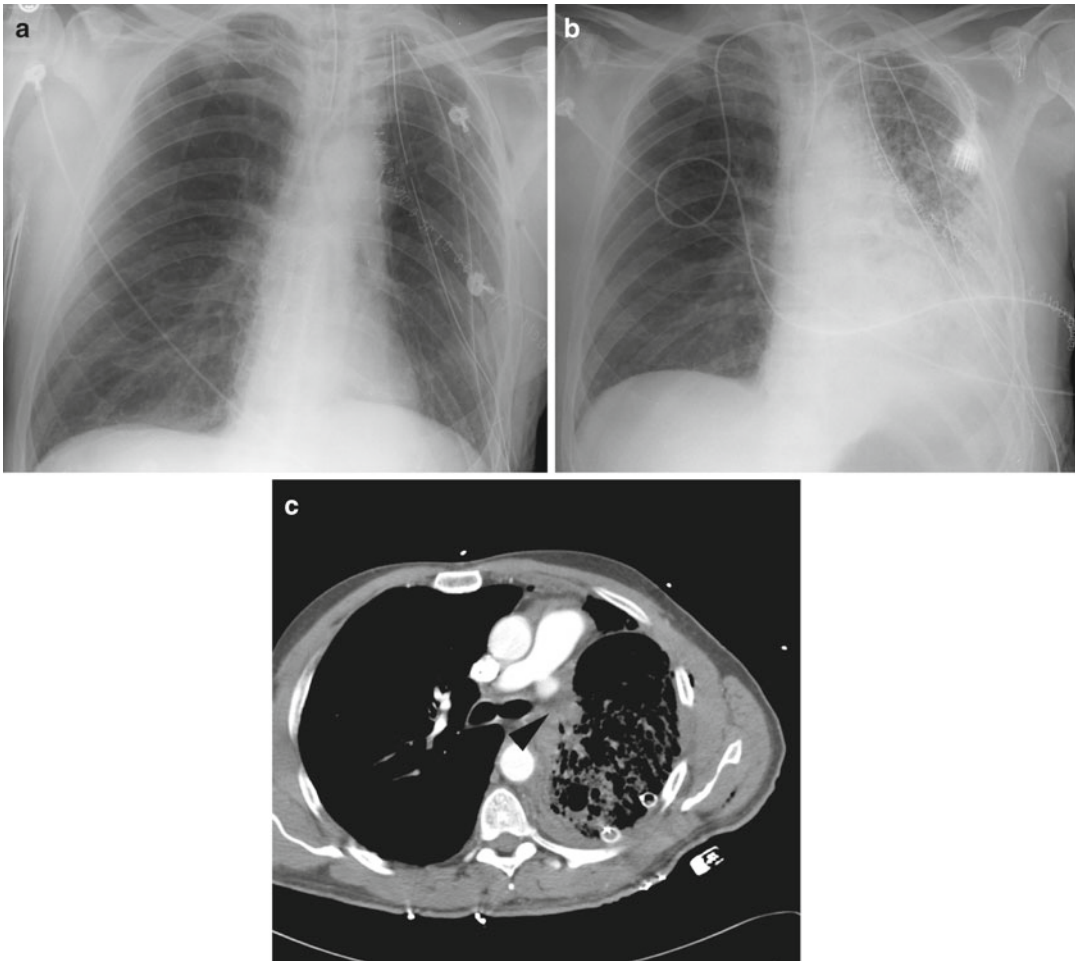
Postoperative lobar torsion. (a) Frontal radiograph on postoperative day 1 following left upper lobectomy reveals expected aeration of the remaining left lower lobe. (b) Frontal radiograph on postoperative day 2 reveals rapidly progressive air-space opacities in the remaining
